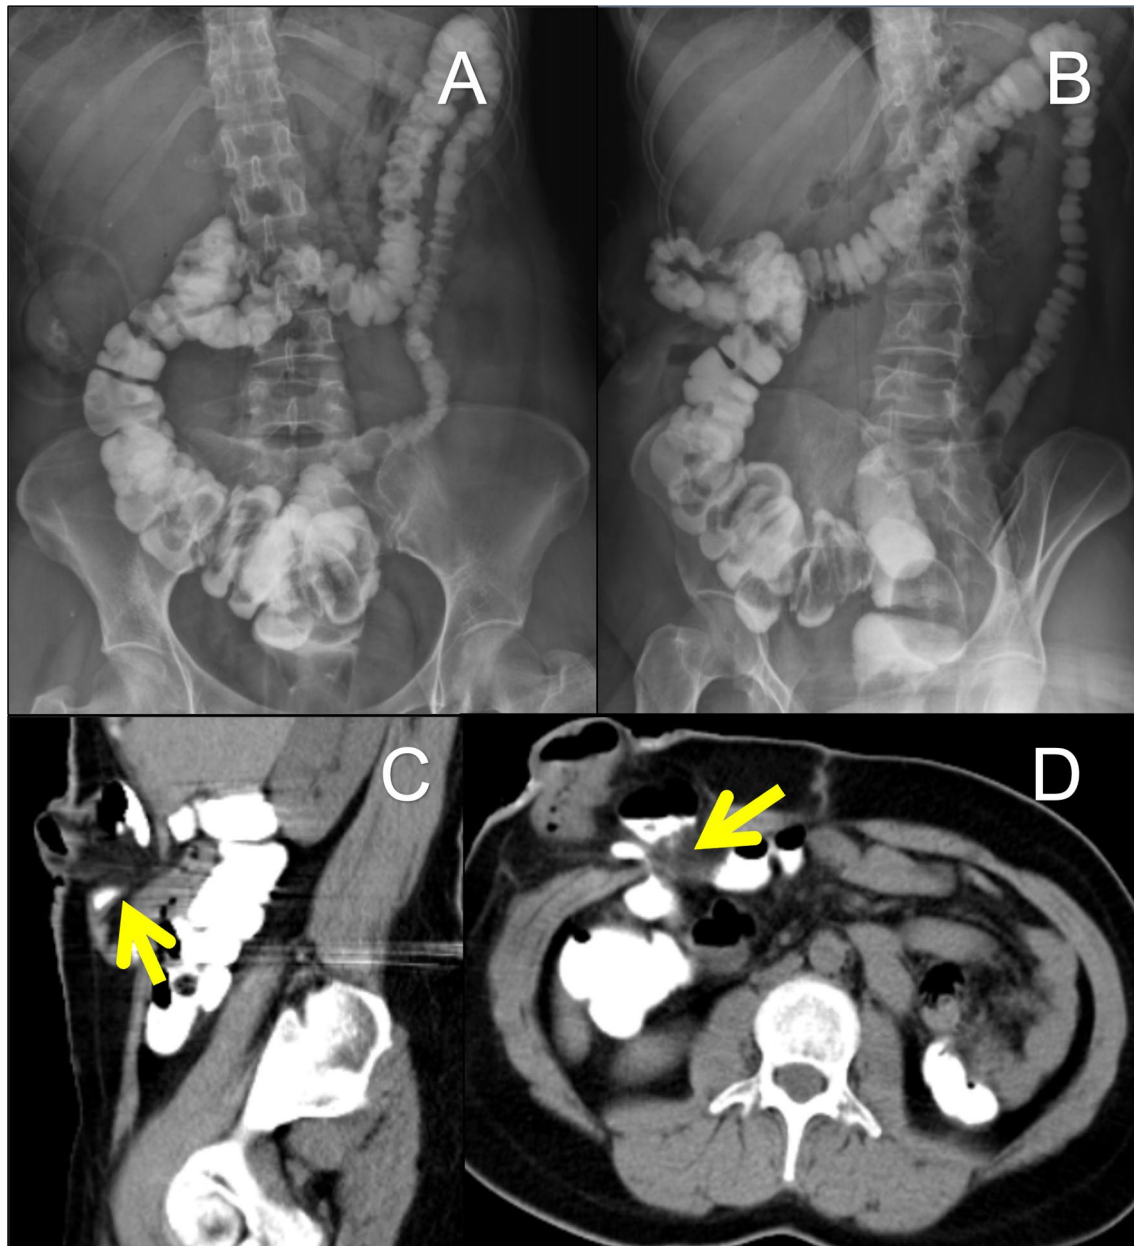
38-year-old female patient with history of colon cancer underwent surgical resection and ileostomy, referred for assessment of the distal loop pre-stomal closure, WSCE was performed followed by complimentary CT study. A and B AP and left oblique view of water-soluble contrast enema under fluoroscopic guidance shows free flow of the administered contrast material down to the anal canal with no stricture, leakage, or filling defects. C and D Sagittal and axial CT study of the abdomen after administration of water-soluble enema revealed the presence of parastomal hernia containing ileal and colonic loops, with mild diffuse mural thickening (yellow arrows). Accordingly, the surgical management was to repair the hernia and reverse the stoma on the same session
